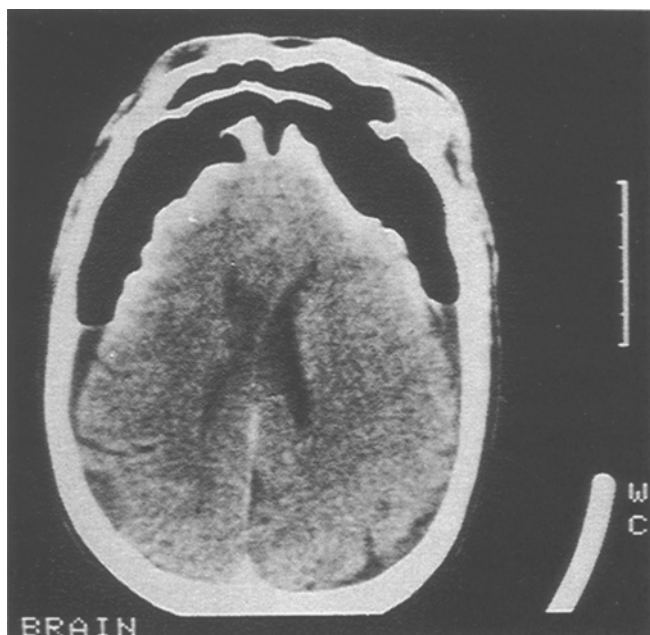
CT brain scan showing a tension pneumocephalus with compression of supra and infratentorial brain
